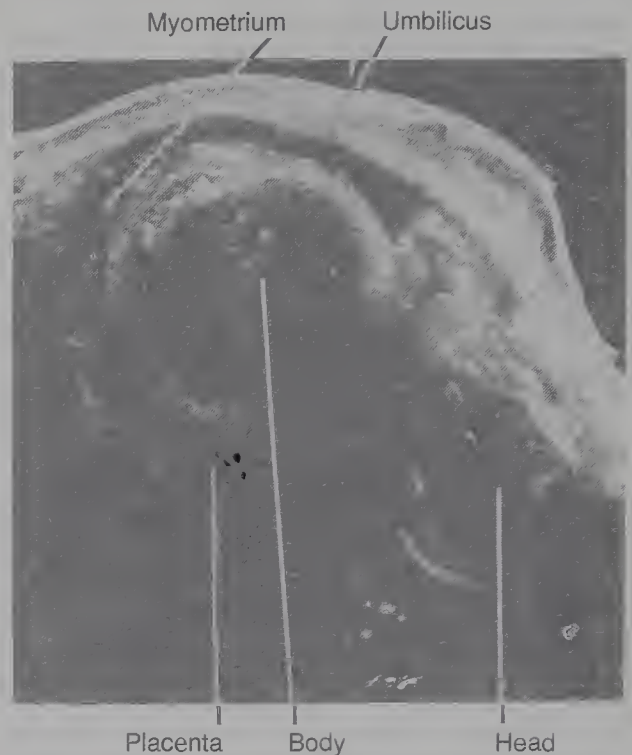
Longitudinal scan through the mid-abdomen of a woman with GDM at 36 weeks. Ultrasonographic documentation of macrosomia. The 107-mm body is disproportionately large when compared with the 89-mm biparietal diameter of the head.
